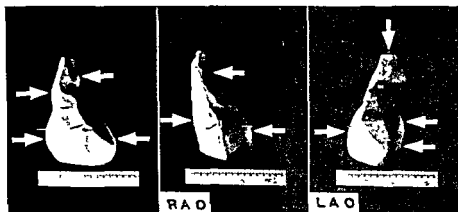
Young female, healthy. Normal heart. Roentgenologic, volumetric reconstruction. Ant view: rt atrium (rt lower arrow). Cranial portion, ascending aorta (rt upper arrow). Distal portion aortic arch (lt upper arrow). Lt ventricle (lt lower arrow). Rt ant obl view: normal, almost straight dorsal border, lt atrium (rt arrow). Ventral contour cranial portion ascending aorta (lt upper arrow). Rt ventricle (lt lower arrow). Lt ant obl view: rt ventricle (rt arrow). Vessels to neck (upper arrow). Lt atrium (lt upper arrow). Lt ventricle (lt lower arrow). Courtesy Prof Dr G G Palmieri, Bologna, Italy.
